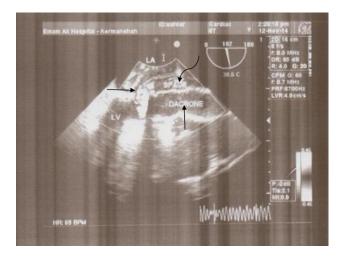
Transesophageal echocardiography revealed the origin of a pseudo aneurism orifice (transverse arrow), pseudo aneurism space (curved arrow), and Dacron tube (vertical arrow).
